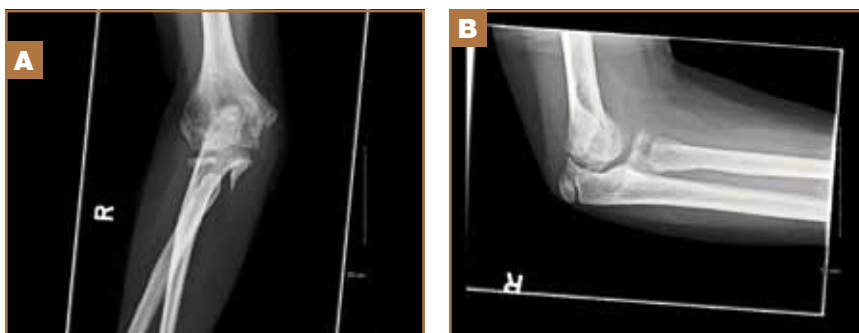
Anteroposterior (A) and lateral (B) radiographic images show persistent subluxation of proximal radial epiphysis and interval bridging callus formation.
